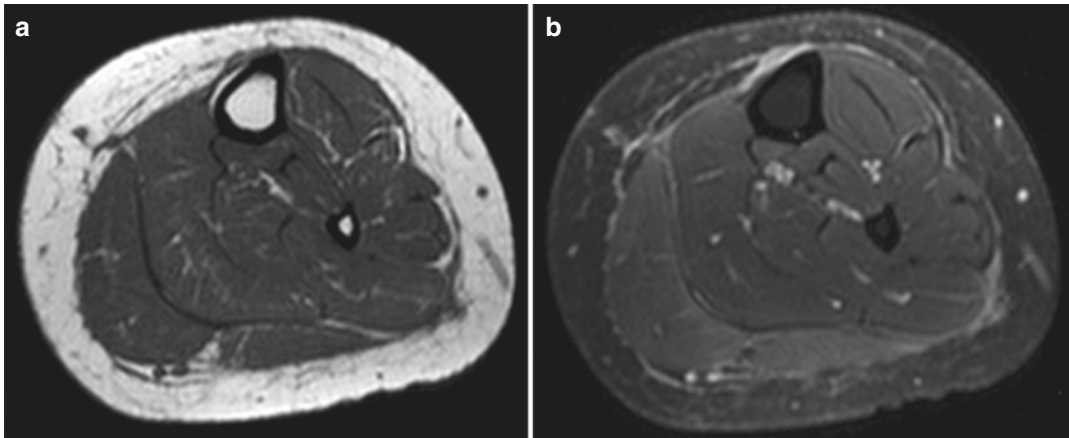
MRI images showing periosteal edema along the anteromedial border of the tibial diaphysis in (a) axial T1 and (b) Axial T2 Fat Sat views
